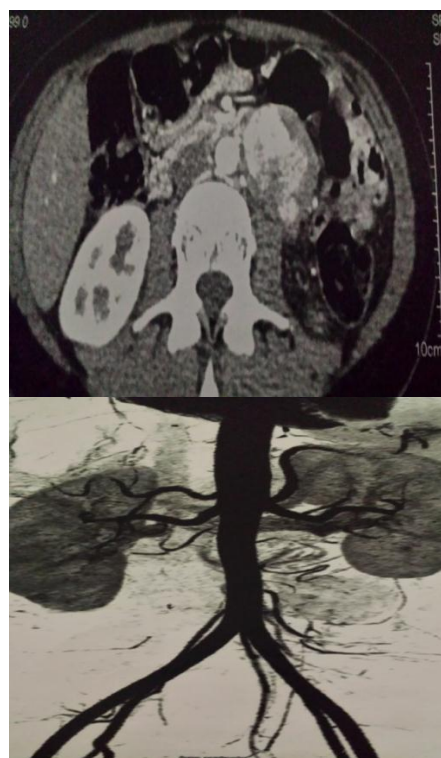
CT image of the paraganglioma of the organ of Zuckerkandl.
